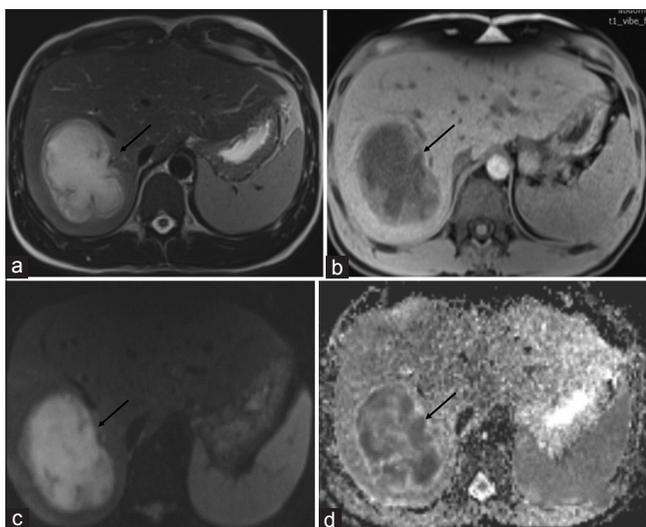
Axial T2 weighted MR image showing large hyperintense lesion with Hypointense rim in right lobe of liver (black arrow, a). Axial T1 weighted MR image showing large homogeneously hypointense lesion with hyperintense rim in right lobe of liver (black arrow, b). Axial DW MR image showing hyperintense signal in the lesion (black arrow, c). ADC map showing heterogeneously hypointense signal corresponding to hyperintense signal areas on DWI within the lesion which signifies diffusion restriction (black arrow, d)
